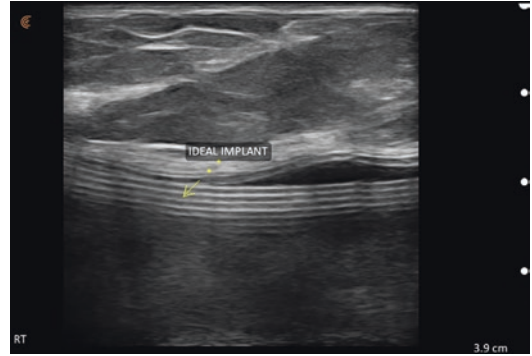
Grayscale ultrasound image of a structured saline implant (Ideal implant, Dallas, Texas) showing a shell within a shell configuration
